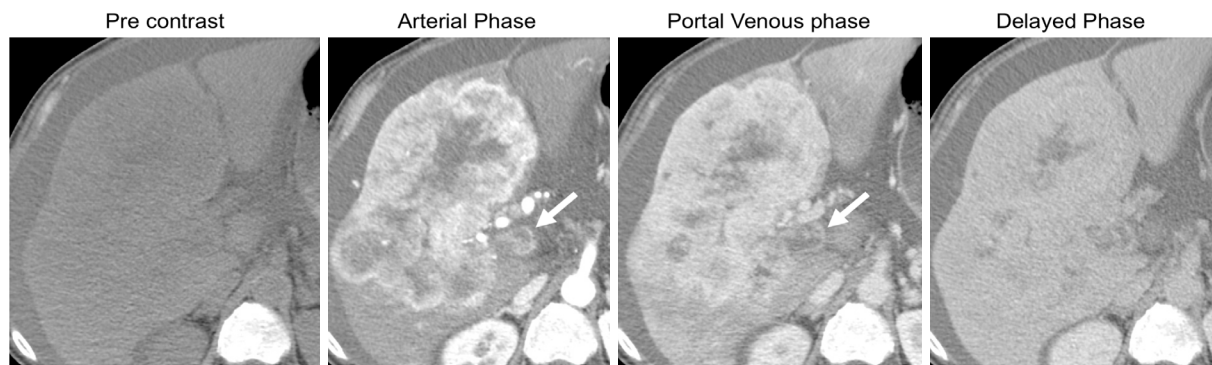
Contrast enhanced CT: 70 year-old male with chronic hepatitis B. A 120-mm mass in the right liver lobe exhibits a targetoid appearance in the arterial phase with central progressive enhancement in the portal venous and delayed phases, indicating a LR-M observation. There are also features of tumor in vein (arrows), shown as portal vein expansion with heterogeneous contrast enhancement. Biopsy results indicated a cholangiocarcinoma
